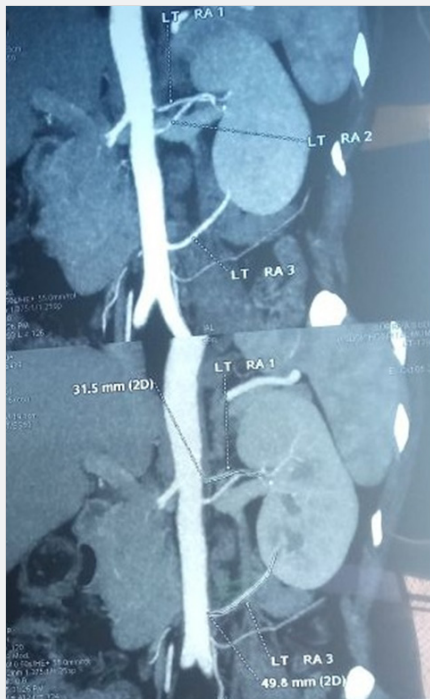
Computed tomography Angiogram- Reconstructed images showing 3 left renal arteries. Two arteries are supplying at the hilum of the left kidney. Third artery is supplying at lower pole of kidney.
